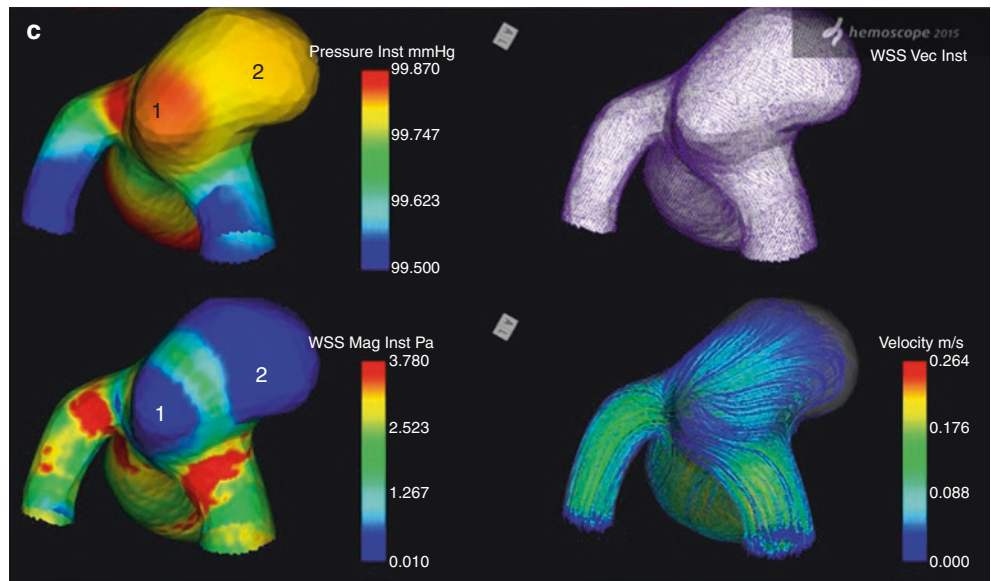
Patient n.11. (a) 3D CT-scan reconstruction of the Acom aneurysm. (b) Intraoperative inspection demonstrating a yellowish and thick area (2). (c) Intraoperative endoscopic inspection revealing a second yellowish and thick area (1). (d, e) CFD analysis showing different
